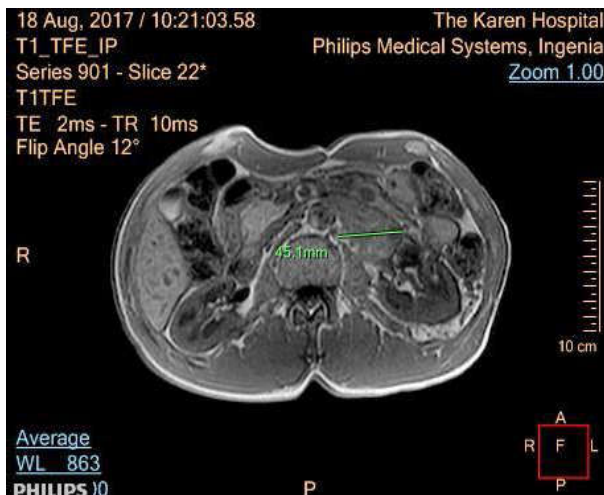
MRI T1W\_TFE Axial View
